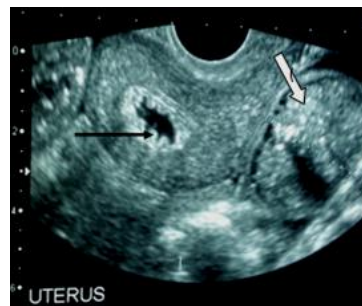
Longitudinal endouterine ultrasound scan showing serpiginous structure within the uterine cavity related to convoluted valves (→) and distended small-bowel loop containing echogenic material beside the uterus (←).
